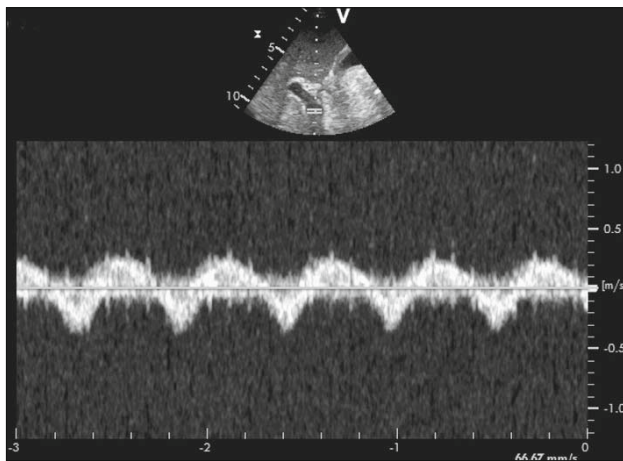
Pulse Doppler measurement. Biphasic flow in the portal vein in a patient with severe right ventricular failure and liver congestion. The sampling volume is placed before bifurcation of the portal vein. Positive velocity signal is hepatopetal, negative is hepatofugal.
